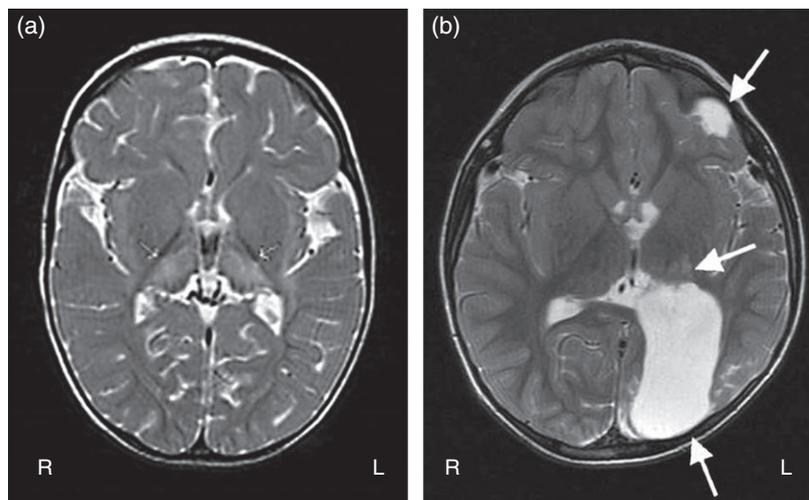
Mild grey matter injury. (a) Brain MRI in a 17-month-old male with history of hypoxic encephalopathy. Axial T2-weighted image demonstrates bilateral, symmetric signal abnormality, and mild volume loss affecting the thalami (arrows). The basal ganglia are spared. (b) Brain MRI in a 3-year-old male with right-sided seizures and right hemiplegia. Axial T2-weighted image demonstrates areas of cystic encephalomalacia in the left frontal and parieto-occipital regions due to parasagittal watershed infarcts (arrows) and ex-vacuo ventricular dilatation, left thalamic gliosis, and volume loss (arrow).
